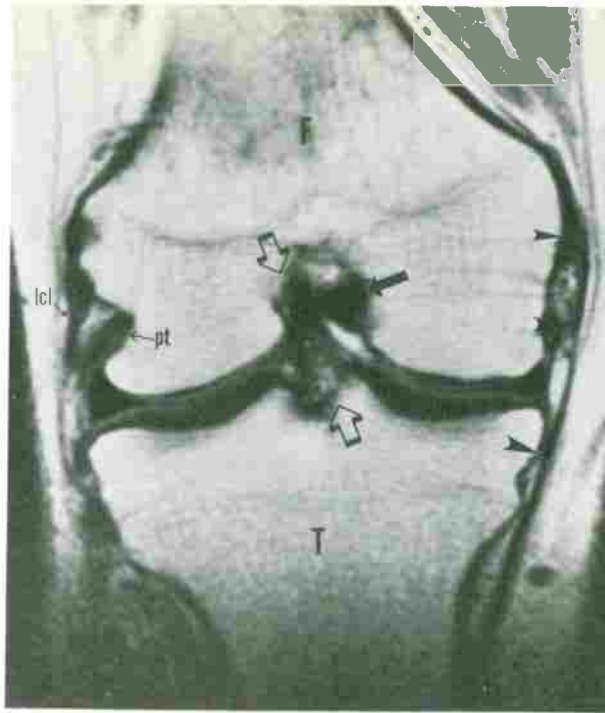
Normal knee. T1-weighted (TR/TE, 800/20) coronal image at the level of the intercondylar eminence tubercles shows the normal MCL as a thin low-signal-intensity band (arrowheads) coursing from the medial femoral epicondyle to the proximal tibial diaphysis. The normal posterior cruciate ligament appears in cross-section in the medial side of the intercondylar notch (arrow). In the distal segment, the normal ACL has an oblique course in the lateral aspect of the intercondylar notch (open arrows). F, femur; T, tibia; lcl, lateral collateral ligament; pt, popliteus tendon.
